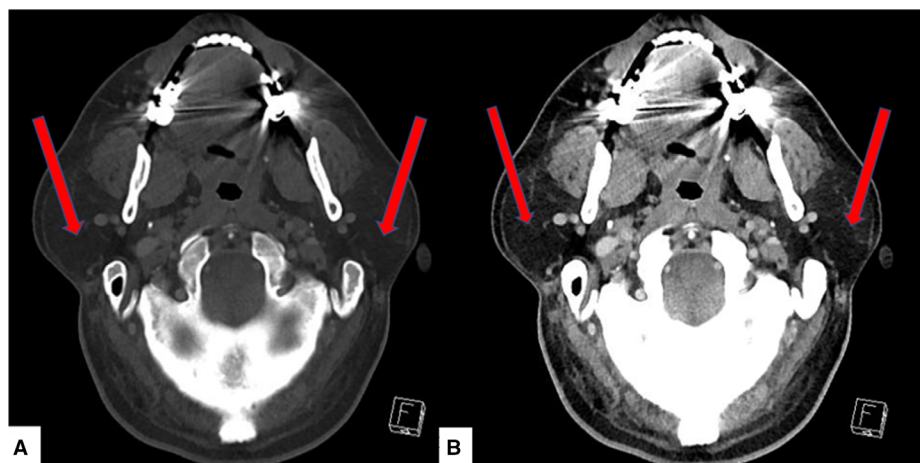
A and B, Axial images of computed tomography (CT) showing both parotid glands prominent in size and almost completely replaced with adipose tissue (red arrows); A and B are in bone and soft tissue windows respectively.
